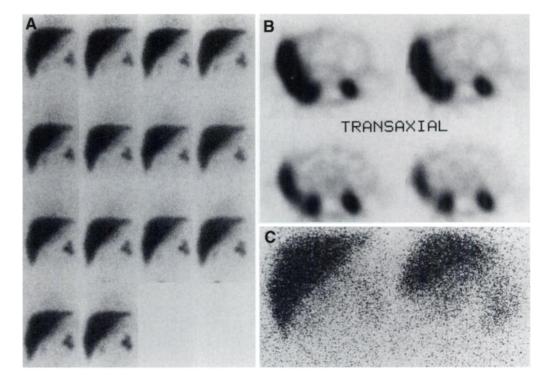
Biliary atresia. A 6-wk-old male infant presented with jaundice and acholic stools. The hepatobiliary scan shows good extraction with a HEF of 100%. At 1 hr (A), 4 hr with SPECT (B) and 24 hr (C), there is persisting parenchymal uptake with no activity visualized in the abdomen.
